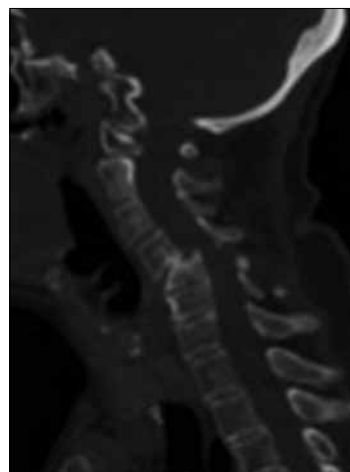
Sagittal computed tomography scan reconstruction demonstrating C4-5 subluxation
